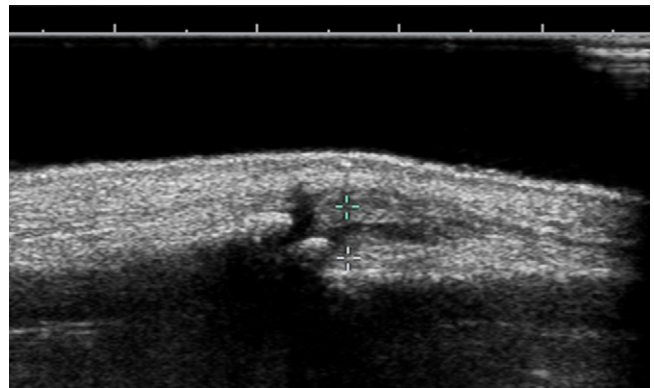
Sagittal dorsal sonographic widthwise measurement of the articular joint capsule distension of a proximal interphalangeal (PIP) 3 joint of a 54-years old female patient with OA. Left side of image is the distal portion of the joint.
